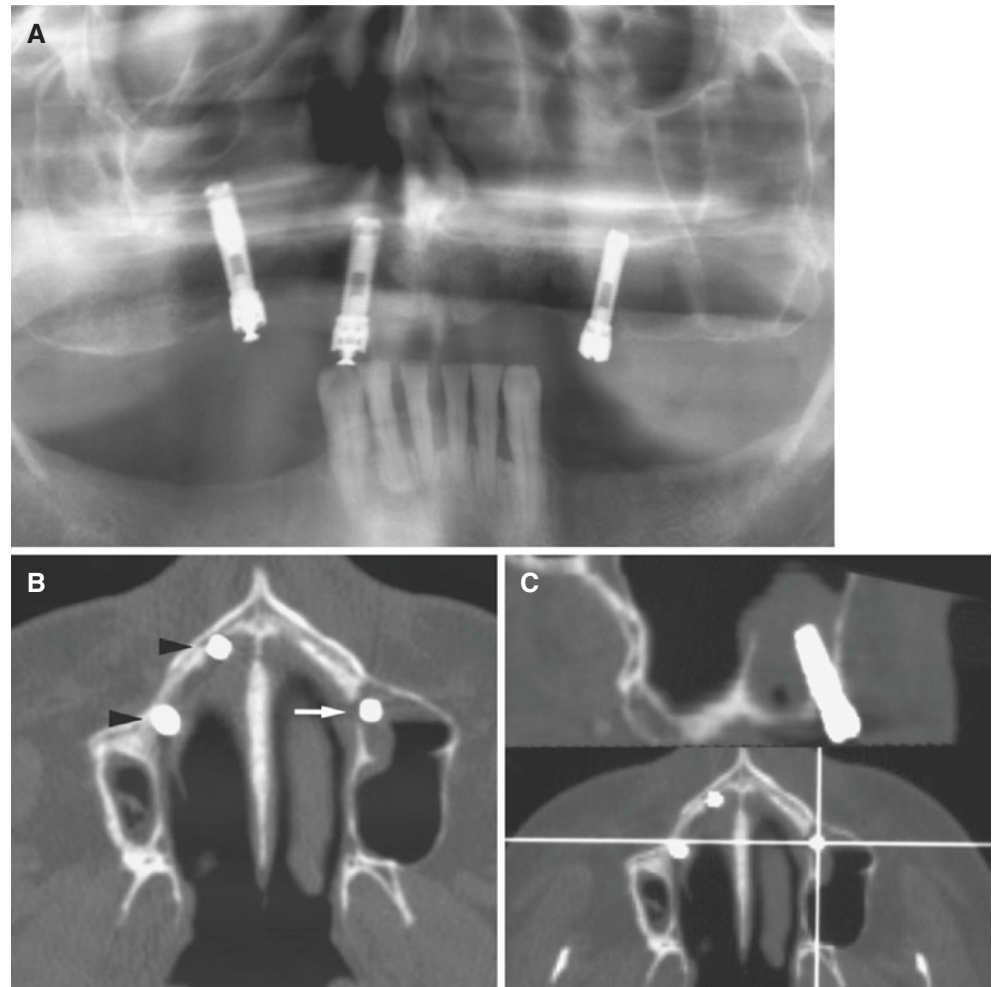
Dental implant complication; 45-year-old male with pain and implants that would not heal adequately (three implants already lost). (A) Panoramic view shows apparently normal bone conditions around three remaining implants, but reliable evaluation is impossible. (B) Axial CT image shows two implants located in the nasal cavity (arrowheads) and one implant located in the maxillary sinus with resorption of medial sinus wall (arrow). Note very small maxillary sinus on the right side. (C) Sagittal CT image (upper), according to cursor line in reference image (lower), shows implant in the maxillary sinus with no bone support other than the sinus wall and some mucosal thickening around the implant
